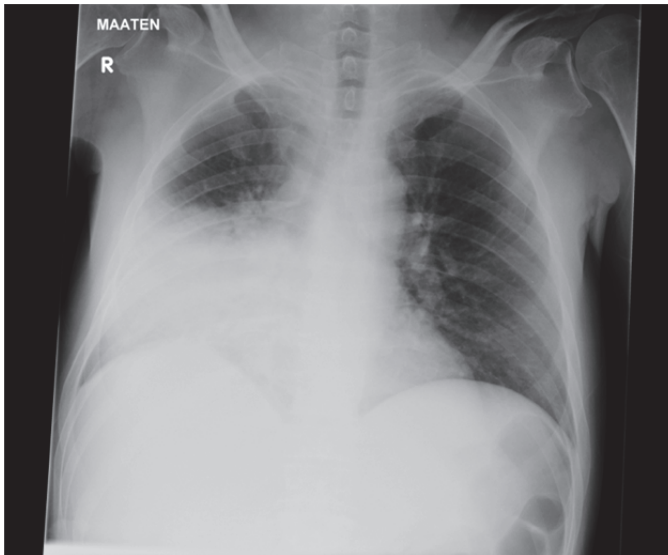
A chest radiograph of a patient with severe community-acquired pneumonia showing lobar airspace opacity in the right inferior lobe.
